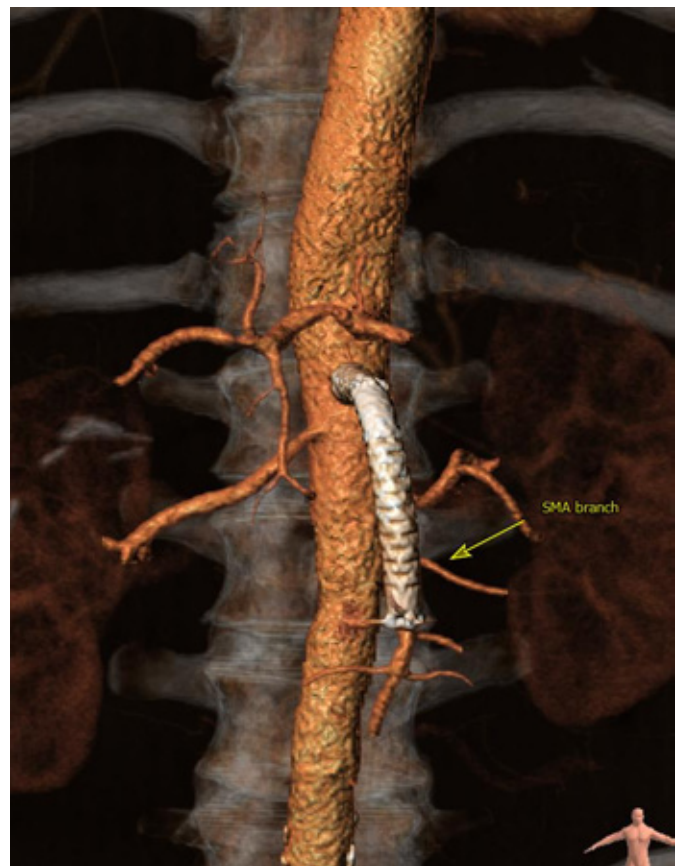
The second case that was treated using stent completed 6 months of follow-up. No complication was recorded. CTA revealed stent and SMA patency. The smaller branches of the SMA were successfully preserved (yellow arrow).
